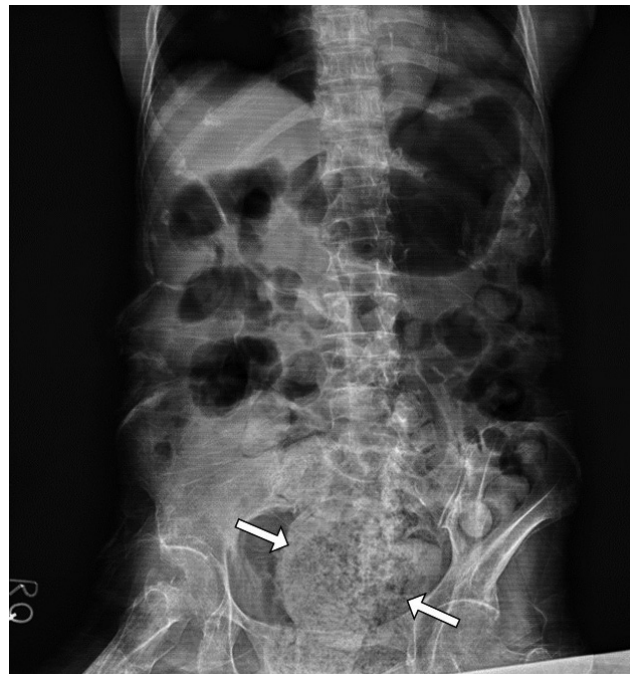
Abdominal X-ray revealed plenty of stool-forming faecalomas impacted in the rectum (white arrows).
